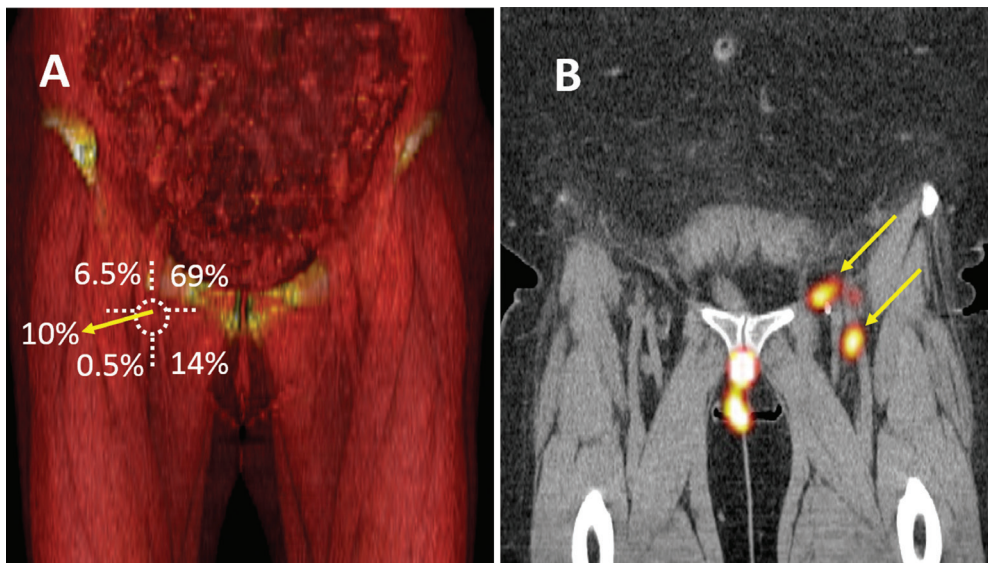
The five inguinal zones of drainage in vulvar cancer according to Daseler *et al.* (A). Coronal fused SPECT/CT image shows one node located in the medial superior inguinal zone and one node in the lateral inferior inguinal zone (yellow arrows) (B).
